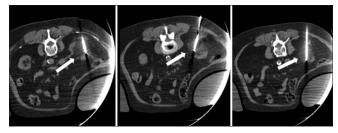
An 82-year-old female who presented for cryoablation of a T1a clear cell adenocarcinoma of the right kidney. Axial CT images during cryoablation demonstrating 3 Ice Force cryoablation needles in the lesion with good ice coverage around the lesion (arrows).
